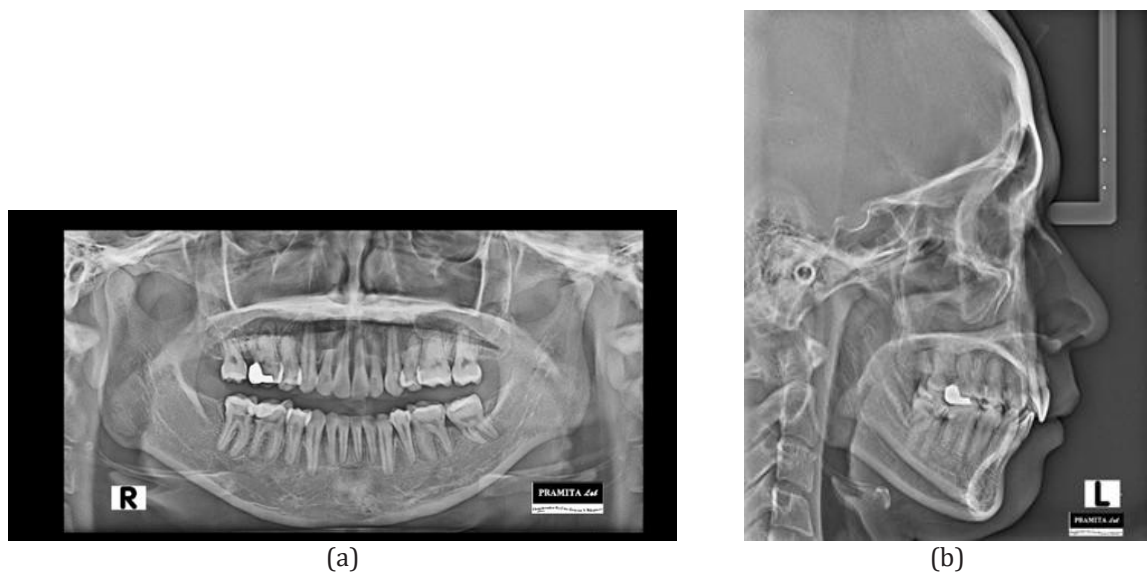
Posttreatment radiograph examination. (a) Panoramic radiograph, (b) Lateral cephalogram.
